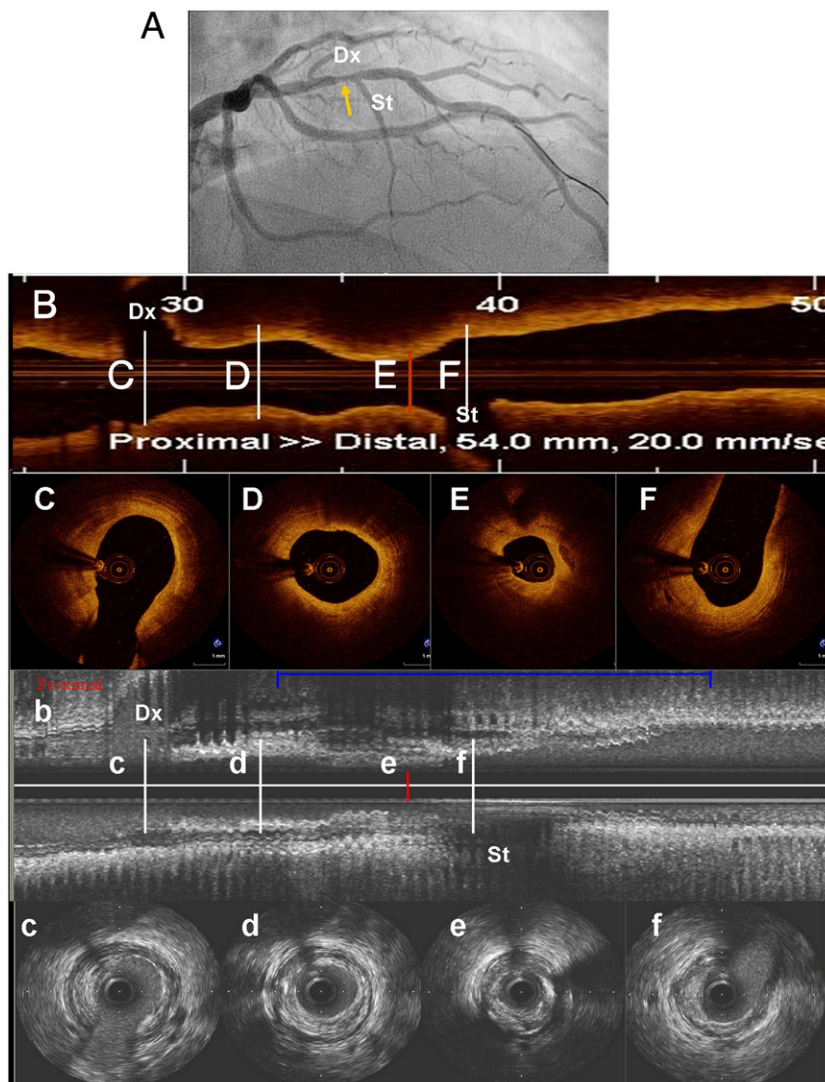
Matching of Optical Coherence Tomography and Intravascular Ultrasound Pullbacks
